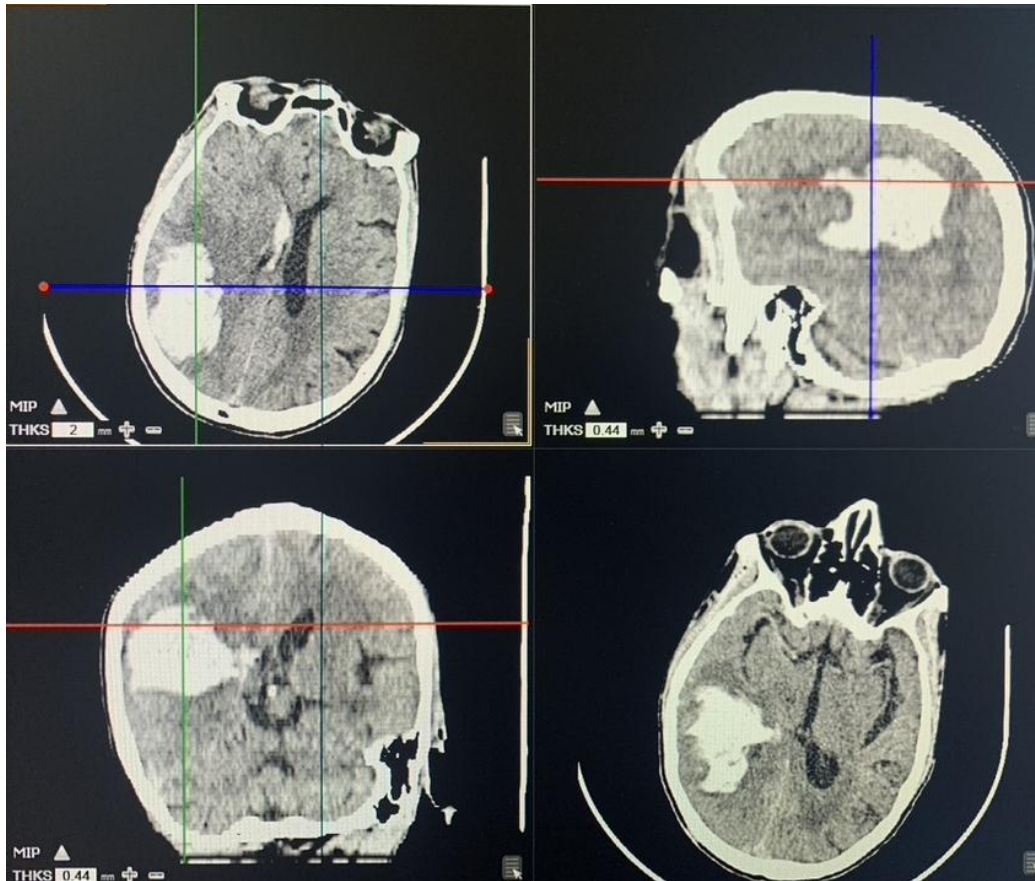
Multiplanar Non-enhanced Brain CT of a 55-year-old male in axial, sagittal and coronal planes. The images demonstrate a right parietal temporal hyperdense lesion with surrounding hypodense area, midline shift and intraventricular hemorrhage.
